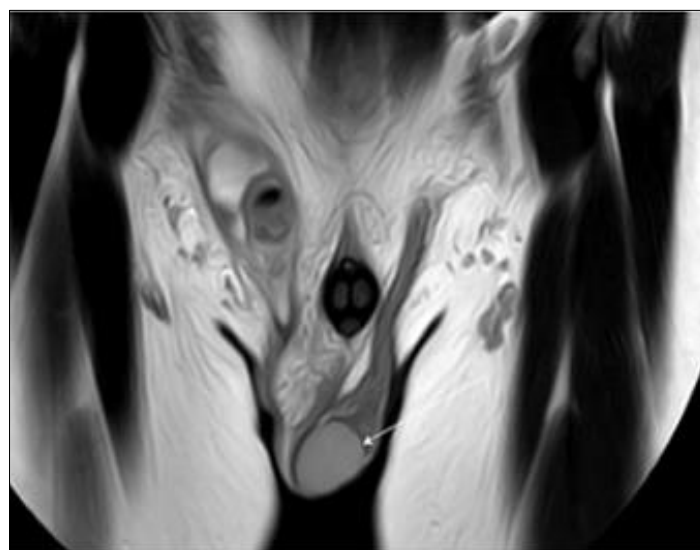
A: abnormal positioning and twisting of the spermatic cord. Enlarged with heterogeneous signal intensity; areas of hypointensity on T1-weighted images and hyperintensity on T2-weighted images
